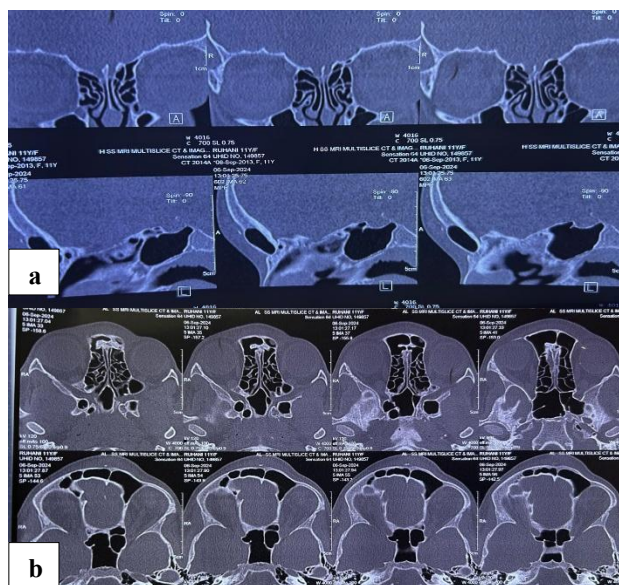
(a) Pre-operative coronal and sagittal CT images showing frontal soft tissue swelling, and (b) axial CT image demonstrating a calcific bony fragment in the lesion.
